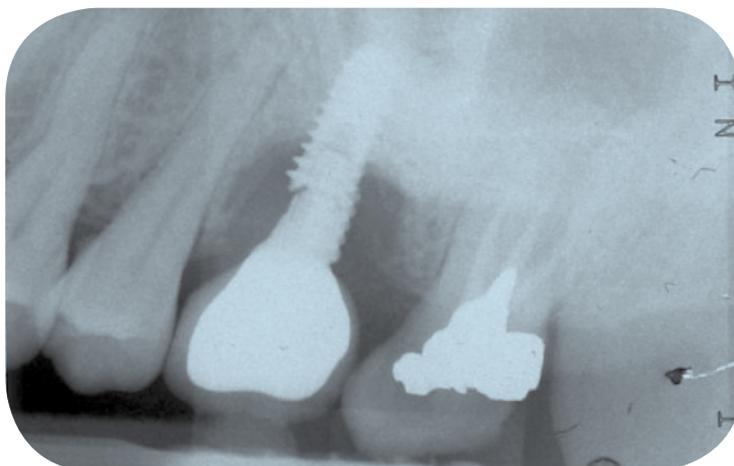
Peri-apical radiograph taken in December 2015
